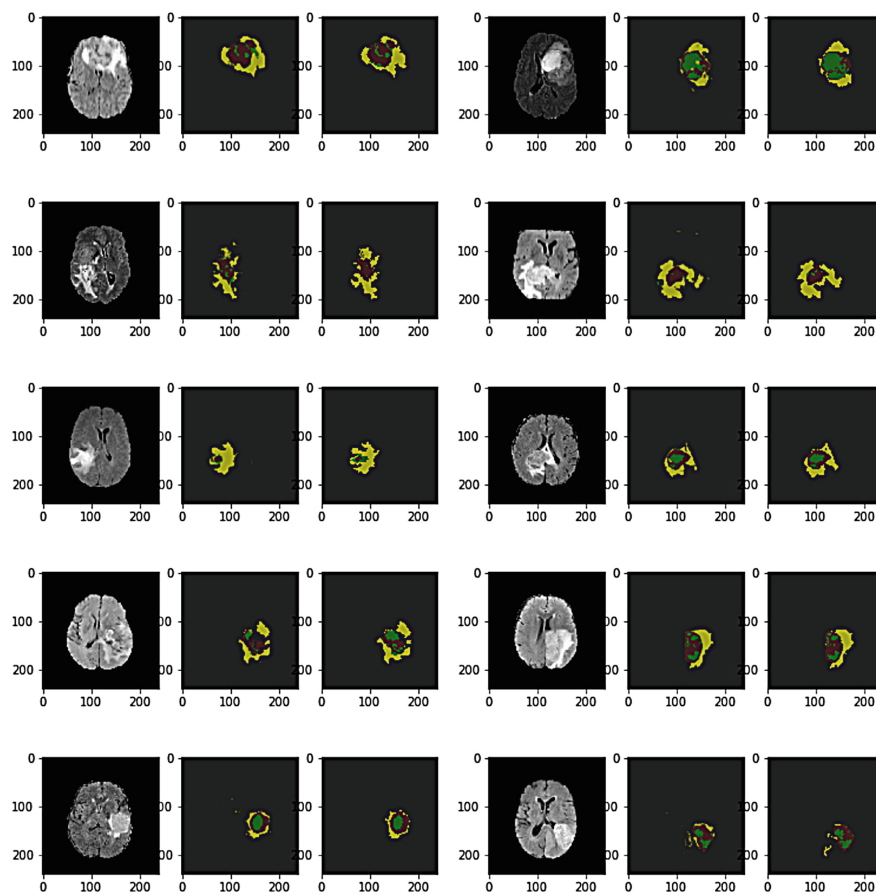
Visualization of 10 random cases. For visualization purpose, ones with all three labels were selected. Each case is a set of three displays, which the left is the image (X) of the FLAIR modality, the middle is the prediction labels (Y_p), and the right is the manual segmentation labels (Y_t). For the label colors, Green: Necrosis+Non-enhancing Tumor, Yellow: Edema, Red: Enhancing Tumor. (Color figure online)
